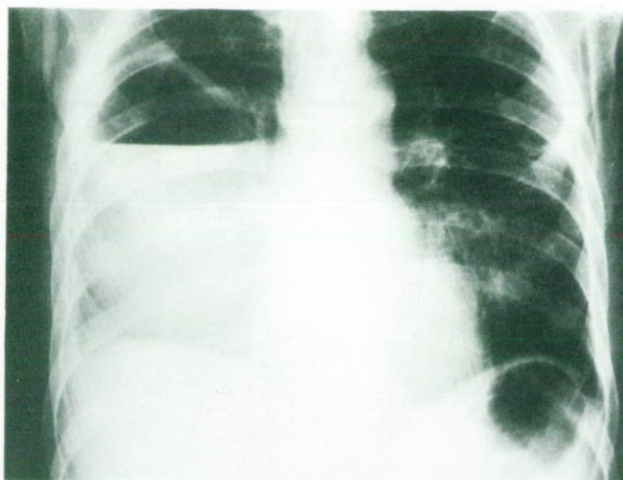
(A) PA chest radiograph and (B) lateral showing a large loculated fluid-filled cavity situated posteriorly in the right lung. Three attempts at aspiration failed before ultrasound was used to identify the correct site for aspiration.
